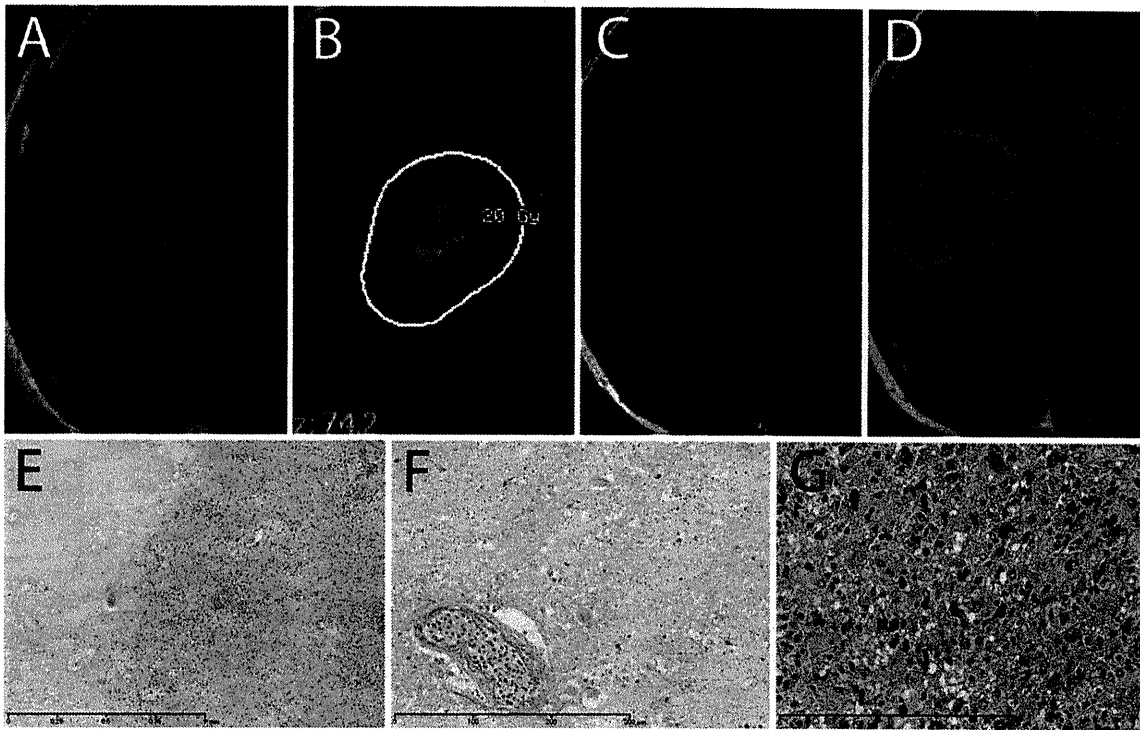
Case 1 in Table 2 is shown: (A) axial gadolinium-enhanced T1-weighted magnetic resonance imaging (MRI) at presentation; (B) dose planning of stereotactic radiosurgery for recurrence; (C) MRI taken at 1 month after stereotactic radiosurgery showing diffuse enhancement around treated lesion; (D) MRI taken at 25 months after stereotactic radiosurgery showing no recurrence.
